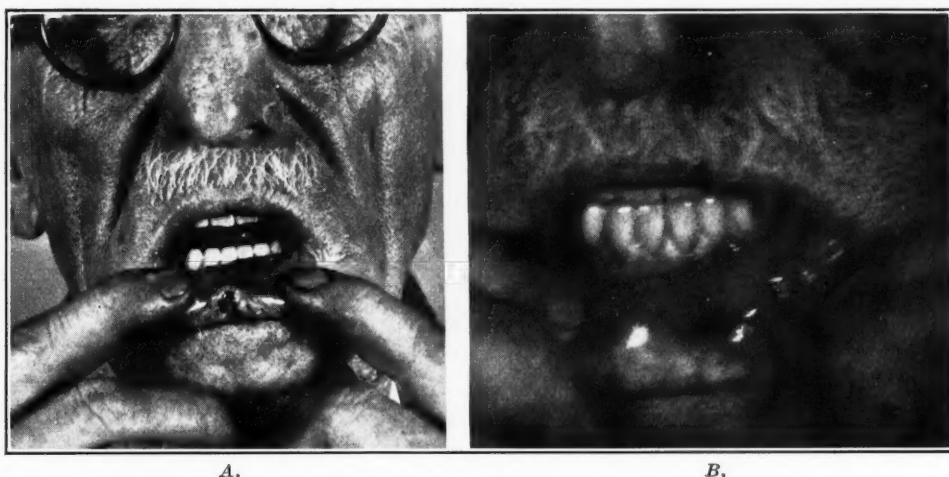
Ulcerative infiltrating squamous cell carcinoma of the lip. *A*, Before irradiation; *B*, following 6000 roentgens of high voltage radiation. Free from disease seven years after treatment.
